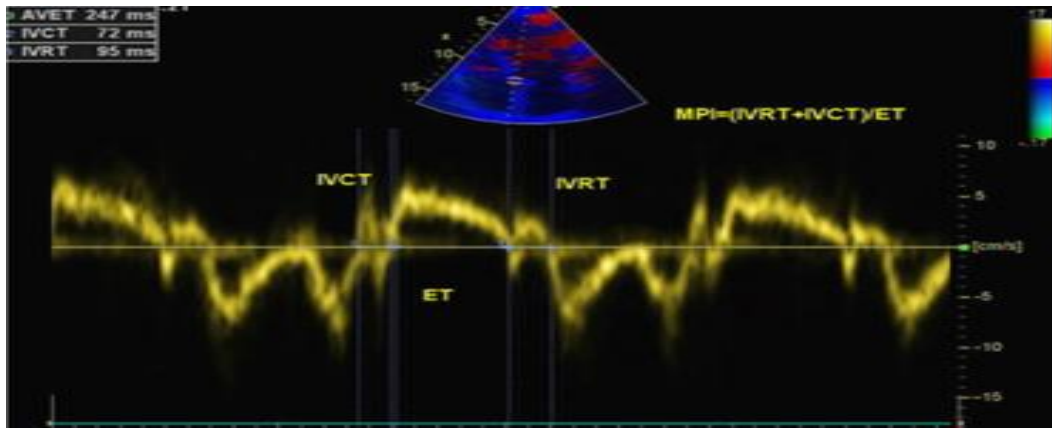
Measuring MPI using tissue Doppler imaging.
